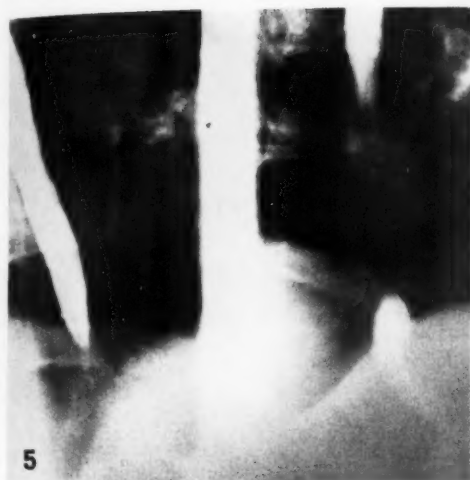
Case II: Conventional radiographic technic showing "normal" esophagus.
